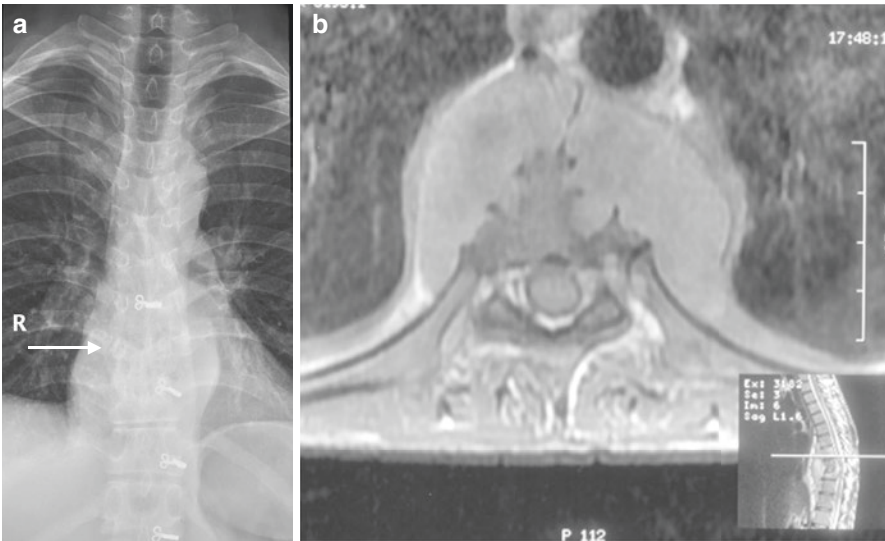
Chest X-ray PA view (a) of a patient with tuberculosis D8–10 vertebrae seen as a retrocardiac shadow.(arrow) Axial T1 weighted MRI (b) of the same patient reveals a pre and paravertebral abscess at D8 level
